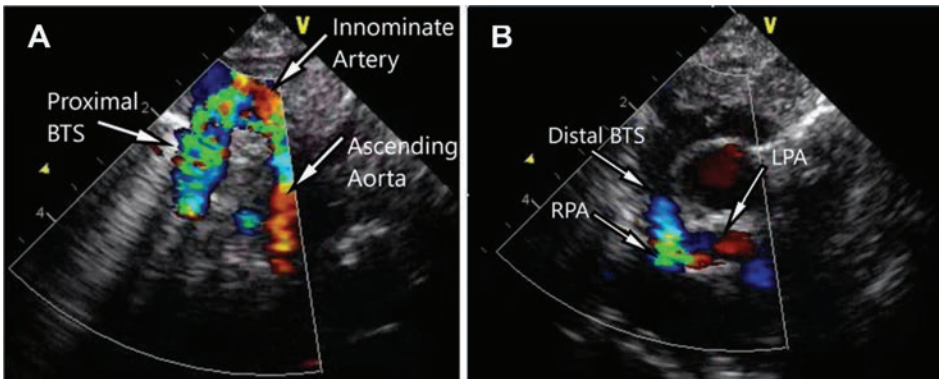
Echocardiographic suprasternal notch view showing the proximal (A) and distal (B) ends of a patent mBTS.
